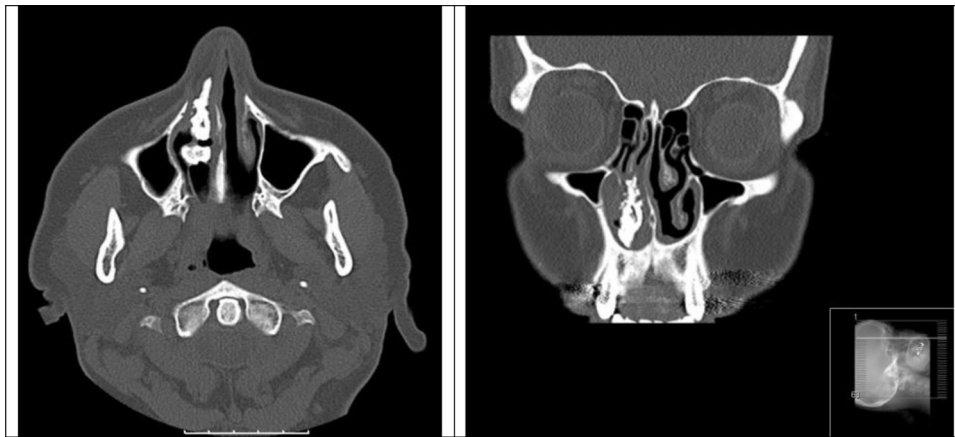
CT images confirming the rhinolith.
